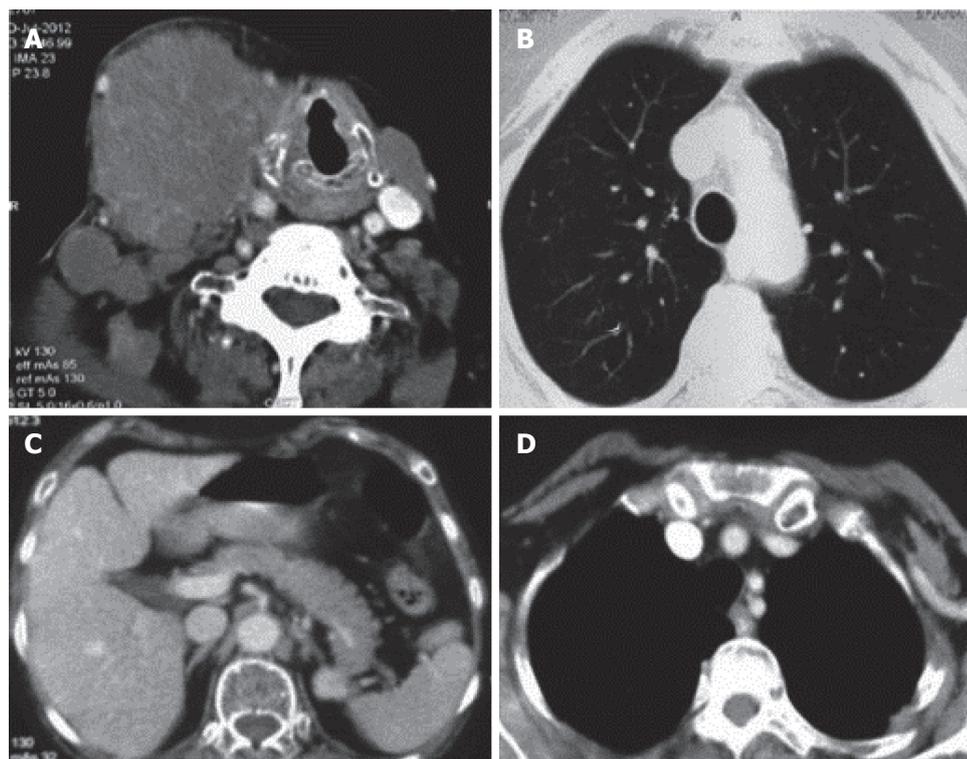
Thoracic imaging at baseline and after treatment of case 2. A: Contrast enhanced computed tomography of the neck revealing a conglomerate lymph node mass of size 7 cm × 4 cm involving the right submandibular region. The mass is pushing the larynx towards the left side; B: Contrast enhanced computed tomography of the thorax (lung window) with no evidence of primary in the lung; C: Contrast enhanced computed tomography of the abdomen with normal abdominal organs and no evidence of any primary in the abdomen; D: Mediastinal window of CECT thorax revealing no enlarged lymph node stations in the mediastinum. CECT: Contrast enhanced computed tomography.
